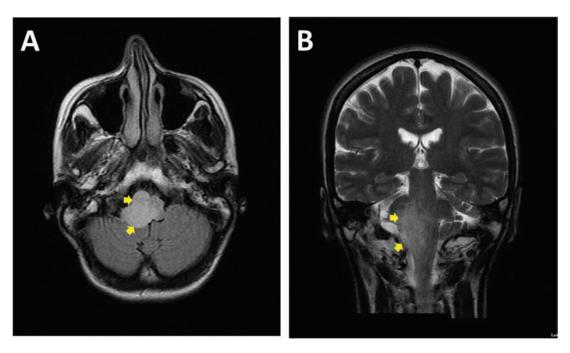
Brainstem glioma predominantly involving the right side of the pons and the medulla (yellow arrows). In this patient, laryngoscopy demonstrated UCAR of the right vocal cord and normal motility of the left vocal cord. (A) Brain MRI axial FLAIR sequence. (B) Brain MRI coronal T2 sequence.
